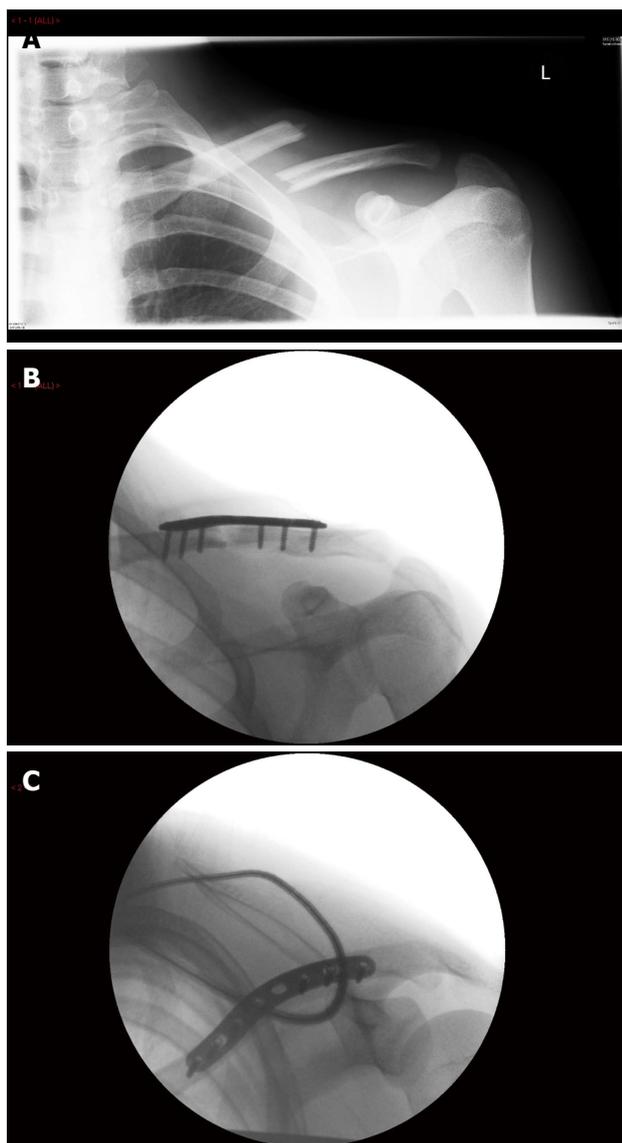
The management of a displaced mid diaphyseal clavicle fracture. A: Pre-operative radiograph demonstrating complete displacement with shortening; B: Intra-operative antero-posterior radiograph; C: Intra-operative skyline radiograph.
